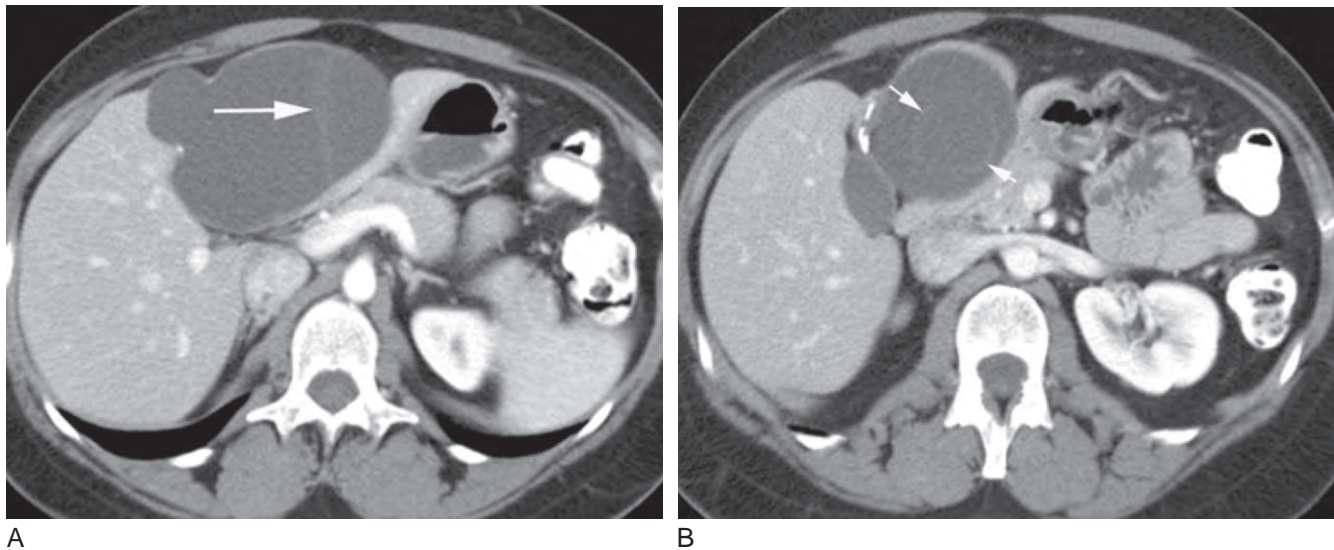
Biliary cystadenoma. A and B, Transverse contrast-enhanced CT images show a cystic mass in the left lobe containing thin enhancing septa (arrows).
